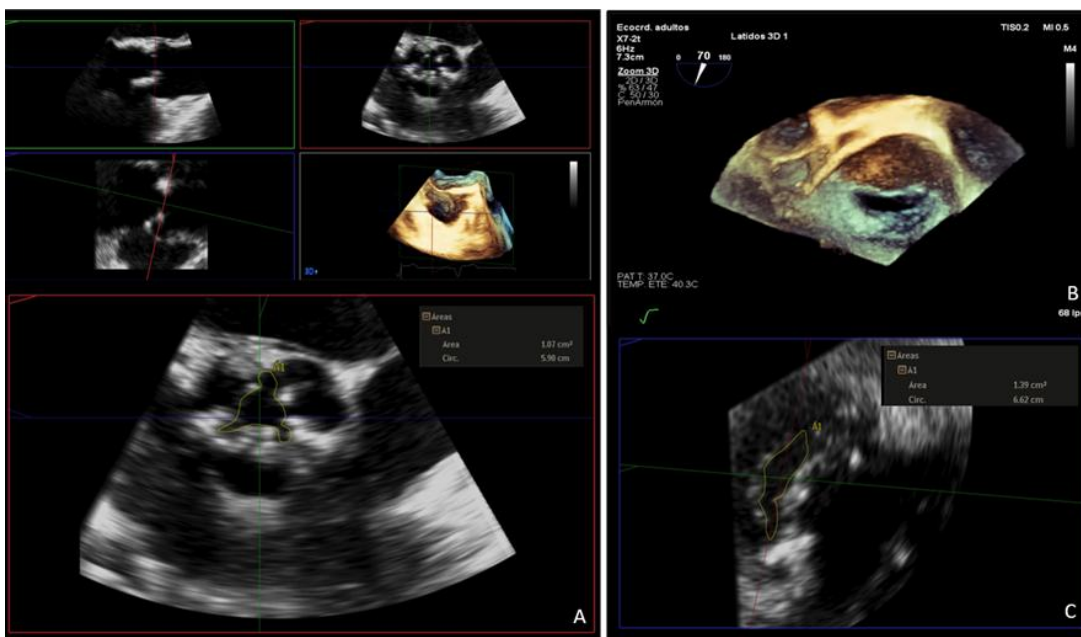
Transesophageal echocardiogram. A: Aortic valve area by three-dimensional planimetry was evaluated; the patient had moderate to severe stenosis. B: Three-dimensional TEE of the mitral valve as visualized from the left atrium reveals thickened leaflets with no commissural fusion. C: Mitral valve area by multiplane reconstruction of a 3D-TEE was assessed; the patient had moderate stenosis.
